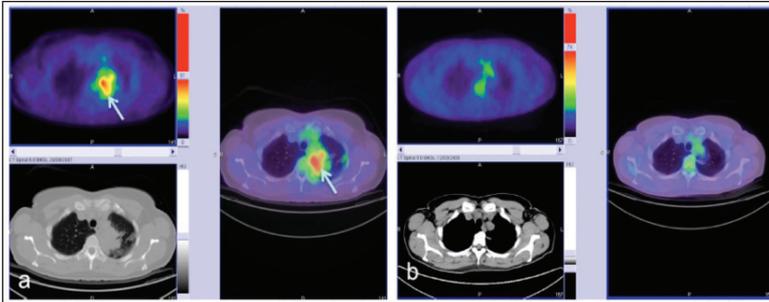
A 52 year old man diagnosed chronic pulmonary Aspergillosis infection presented with dyspnea and cough. He showed positive serologic test to Aspergillus specific Ig E and IgA antibodies. Antimycotic treatment started and a repeat 18F-FDG PETCT study was done after 7 months (b)
